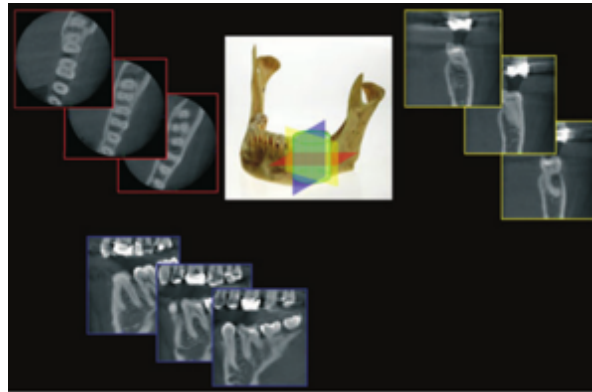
Cross-sectional images in three orthogonal views are generated from the CBCT scan (Patel, S., 2009).
